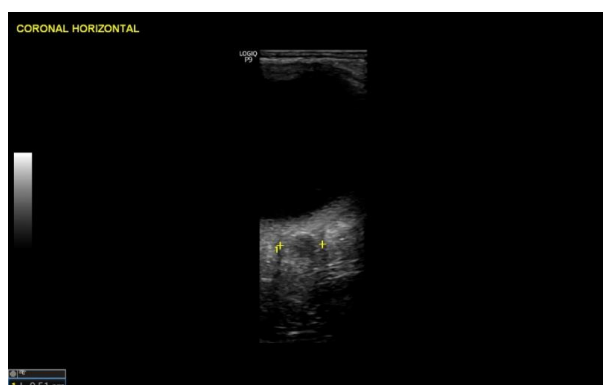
The optical nerve sheath diameter (ONSD) is measured mediolaterally (horizontally on the screen), because this axis should not be disrupted by the oblique view. It is not possible to determine the distance between the optic disc and the measured diameter. The best measurement is the largest mediolateral diameter observed. The Doppler function is not needed. The ONSD is measured inside the inner borders of the dura mater.
